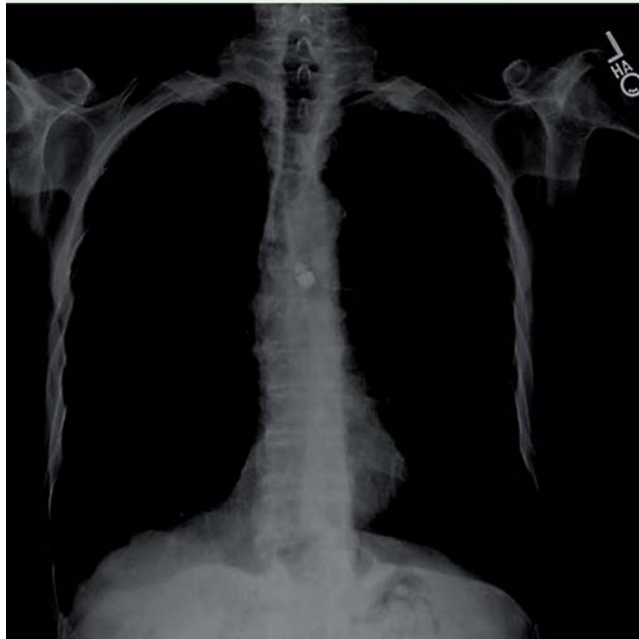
Chest radiograph demonstrating the capsule endoscope in the left main bronchus.
